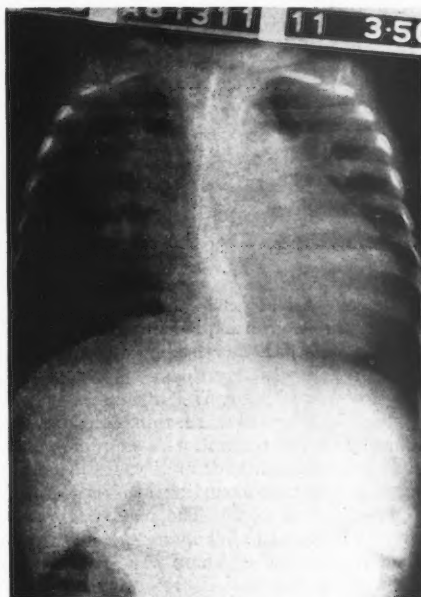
X-ray of chest, aortic septal defect. Patient K. R., case 23, anterior-posterior. Cardiothoracic ratio 64 per cent. Note vascularity of lung fields, large pulmonary artery.
